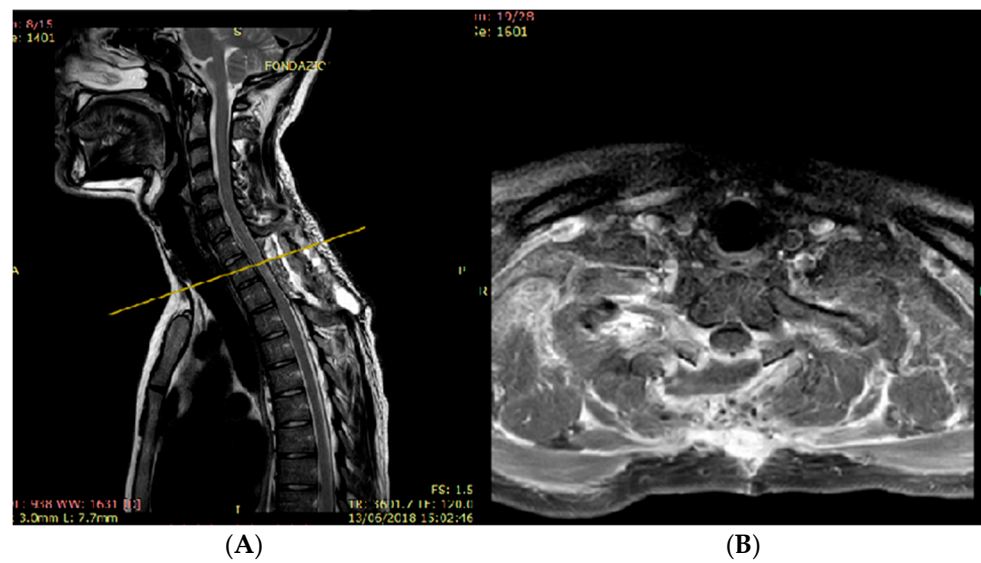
Sagittal T2-weighted MR image (A) showed the total resection of the mass and posterior paravertebral collection at the level of D1–D2, at the site of the laminectomy. Axial contrast-enhanced T1-weighted MR image (B) demonstrated the complete resection of the mass at the level of yellow line.
